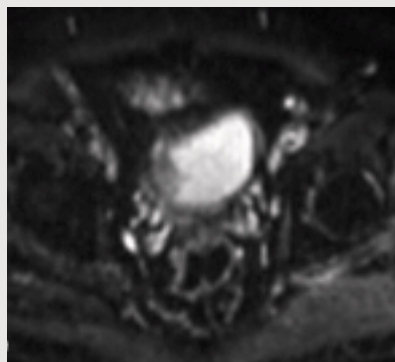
T2-weighted Echo Planar Image (EPI) ($b = 0$)
